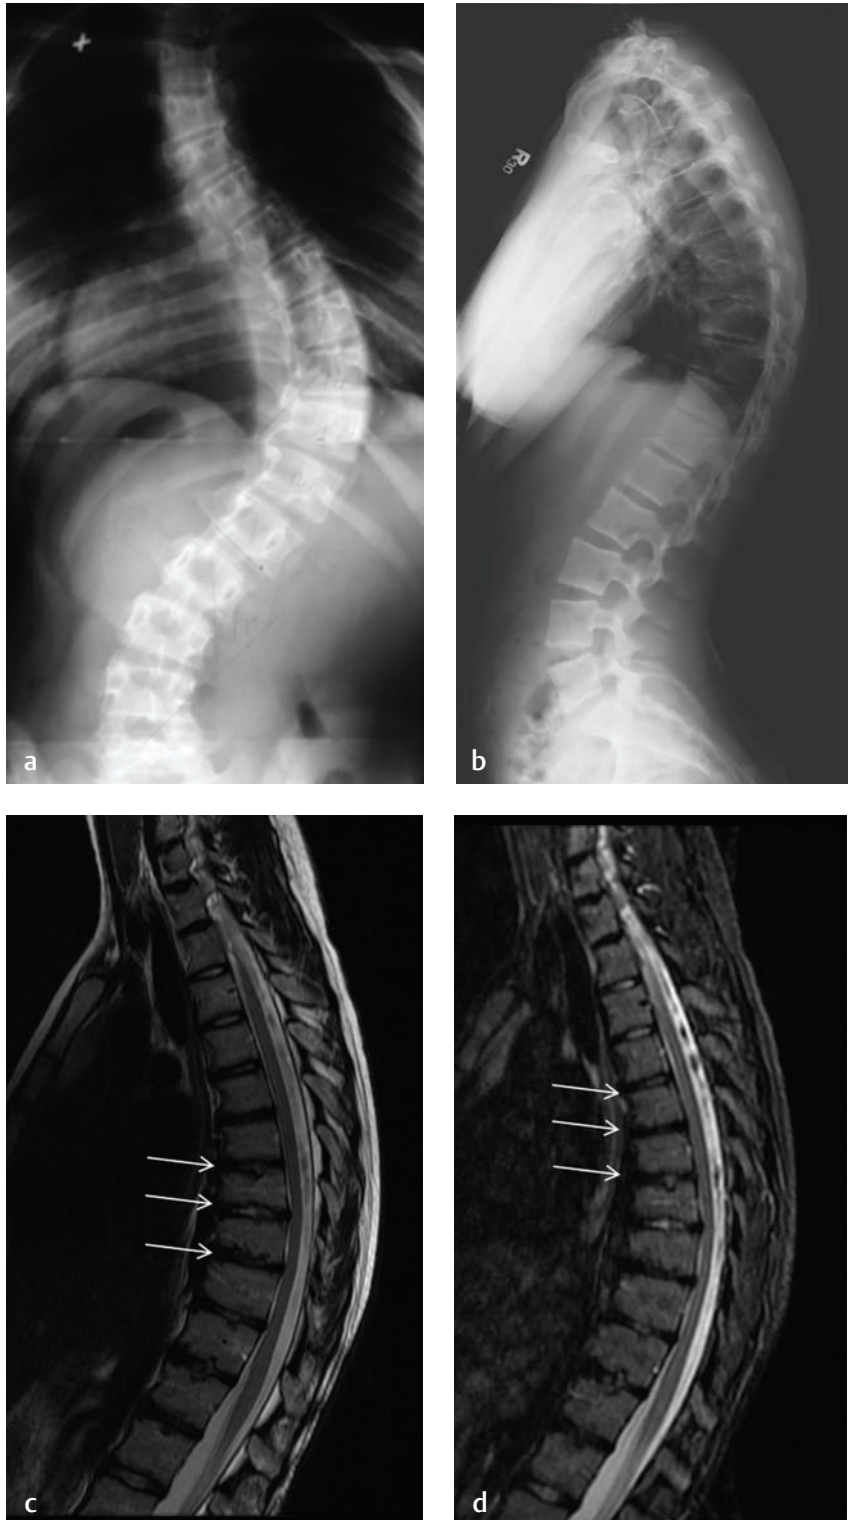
Conventional radiographs: visualization of local and global deformity. (a) A PA radiograph of the spine shows a large right thoracic scoliosis. (b) A lateral radiograph of the spine of another patient shows subtle increased mid-thoracic kyphosis and end-plate irregularities. Because of pain, an MRI study, including sagittal (c) T2-weighted and (d) STIR images, of the thoracic spine was obtained, which better delineated end-plate irregularities and multilevel disc desiccation and herniation (arrows on each) in this young patient, consistent with Scheuermann disease.
